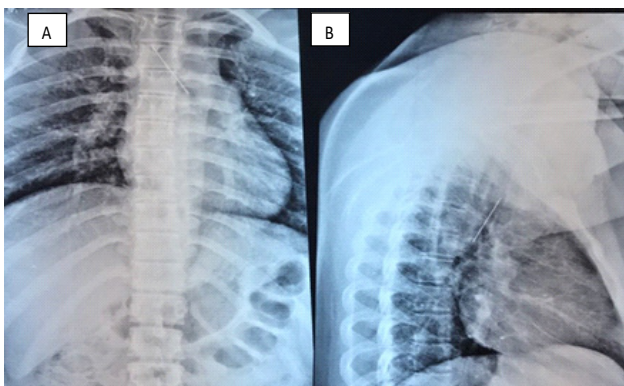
Chest radiograph before bronchoscopy. A. Anteroposterior, B. Lateral
